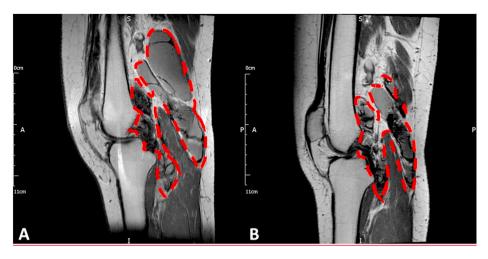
Sagittal T1-weighted MR images of a patient with diffuse-TGCT of the right knee, corresponding with patient 11 in Fig. 4. The dashed red line outlines the posterior knee joint synovial cavity, only a part of this volume is tumour (the hypointense component). A) Pre-treatment MR scan showing diffuse low signal intensity tumour posterior of the posterior cruciate ligament and extending along the distal femoral metaphysis posteriorly and inside the Baker's cyst. B) MR scan after 18 months of IM-treatment with decreased tumour bulk. In addition, the amount of fluid in the popliteal cyst has decreased.
